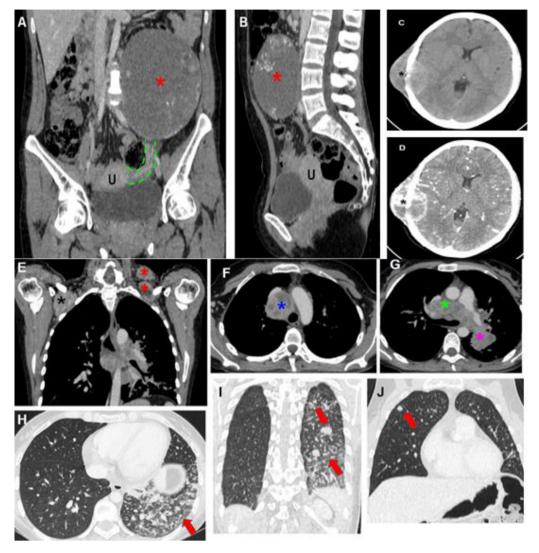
Abdominal and pelvic CT with contrast, coronal (A) and sagittal section (B). Complex cystic formation (*), dependent on the left adnexa, with the left uterine tube (dotted green lines) communicating with the tumour; the solid component represents 30% of the tumour, and the uterus (U) shows normal morphology and size. Brain CT scan, axial view without and with contrast (C, D), shows a solid lesion (*), with a neoformative appearance, in the right parieto-temporal region, causing bone erosion and compression of brain parenchyma. Chest CT scan with contrast in mediastinal window (E–G) and parenchymal window (H–J), in axial view (F–H) and coronal view (E, I, J), which shows solid nodular lesions with a neoformative appearance in the left supraclavicular (*), right axillary (*), right paratracheal (*), subcarinal (*), and left hilar regions (*), as well as multiple solid pulmonary nodes (red arrows).
